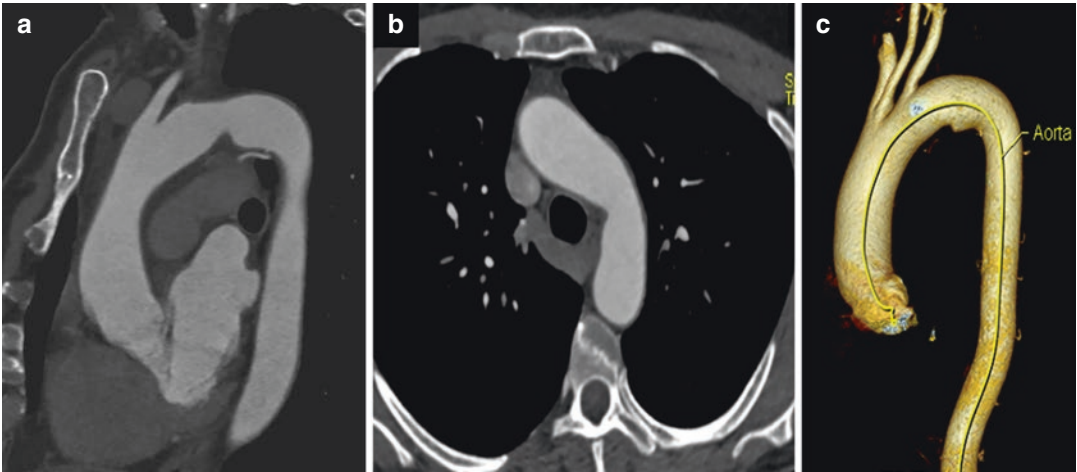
(a) Multiplanar reformation (MPR), oblique reconstruction, (b) axial CT scan, and (c) three-dimensional volume-rendered (3D-VR) image show aortic spindle, regular fusiform mild dilatation of the aortic isthmus
